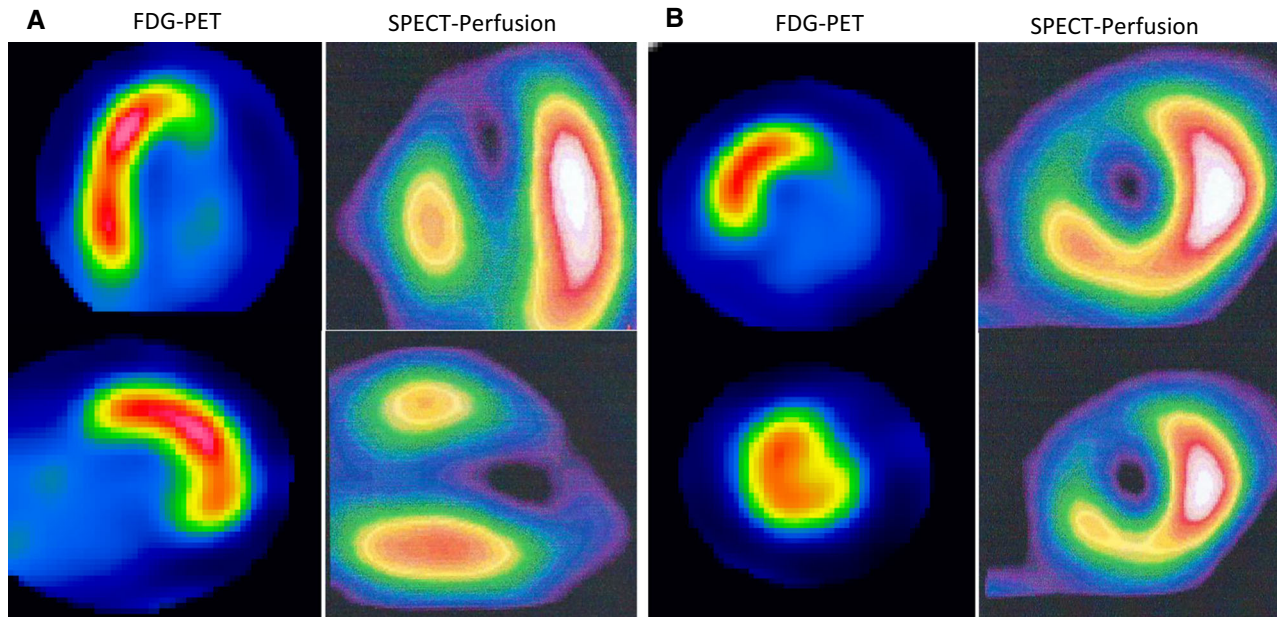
Cardiac ^{18}F FDG-PET and $^{99\text{m}}\text{Tc}$ -MIBI-SPECT perfusion imaging. Horizontal long-axis, vertical and short-axis slices show avid FDG uptake in the septum, anterior wall, anteroseptal, and apical segments and suppression of FDG uptake in the rest of myocardium, with matching segmental defects on the rest SPECT perfusion images.
